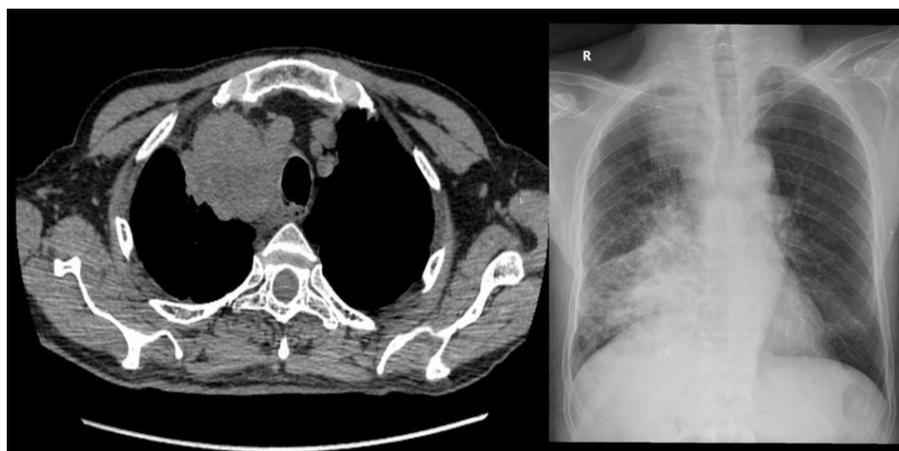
Chest X-ray (PA view) shows homogeneous opacity in the right upper zone extending into the paratracheal region, and a non-homogeneous opacity in the right mid and lower zones with loss of the right cardiac border. CT thorax reveals a lobulated, homogeneously enhancing mediastinal soft-tissue lesion (6.3 × 13.5 × 15.6 cm).
